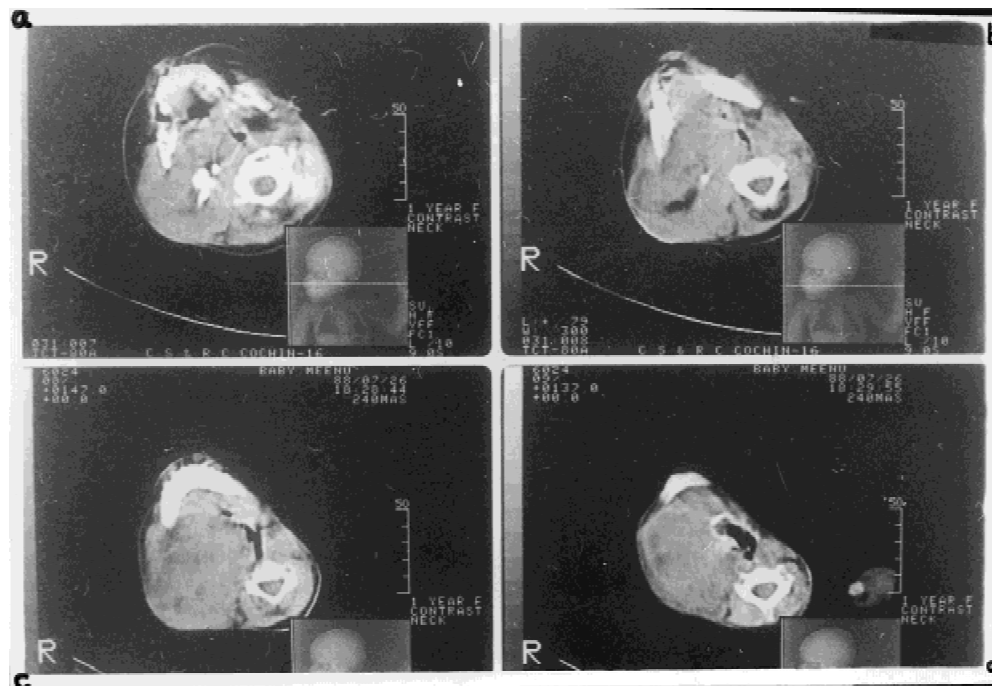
Serial CT scan of case 3 showing a huge mass destroying the mandible, lower border of petrous part of temporal bone and pterygoid plates and partial compression of nasopharynx and trachea.
